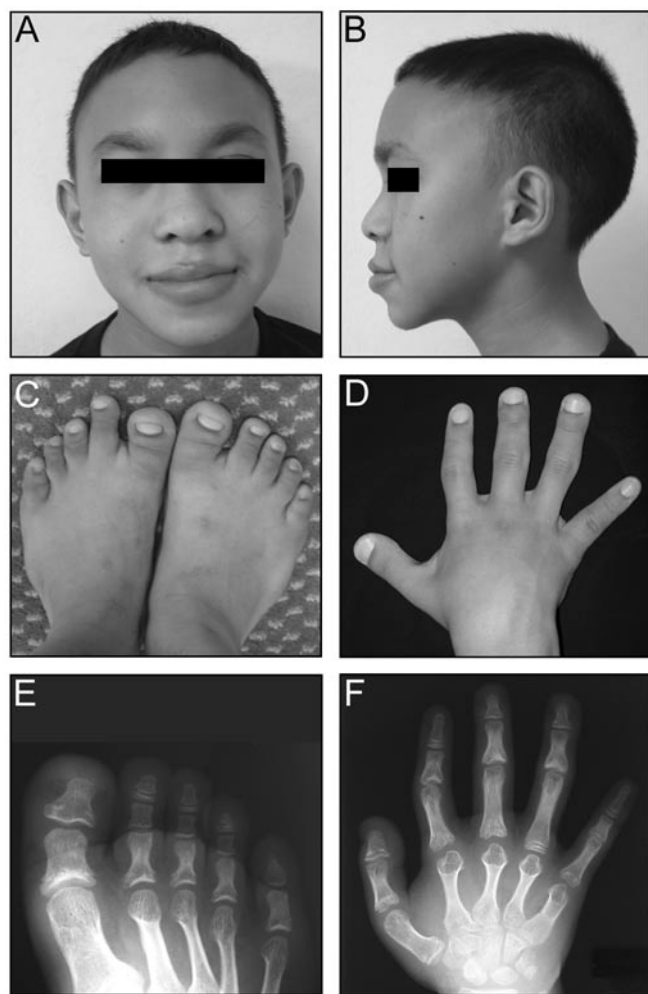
TRPS clinical features of a 17-year-old Thai boy. (A) Frontal picture of the participant showing a high hairline and broad alae of nose. (B) Sagittal view of the individual. (C) Feet with very broad halluces. (D) Hand showing deviation of fingers at proximal interphalangeal joints. (E,F) X-rays of, respectively, foot and hand showing multiple cone-shaped epiphyses.
